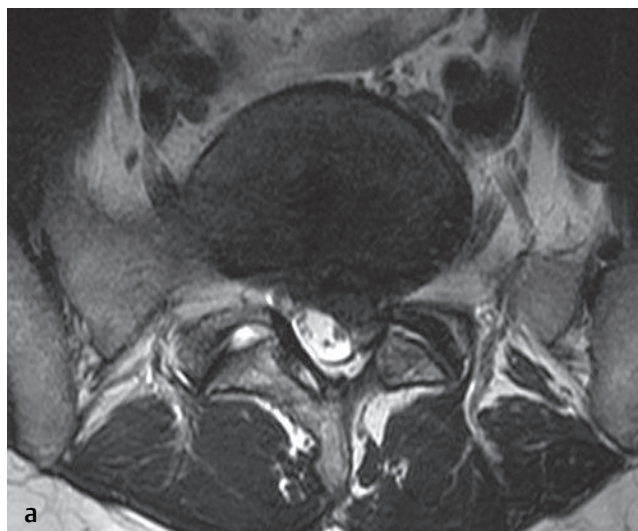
Multiple nerve root contact. (a) This axial T2-weighted image shows a moderate-sized left paracentral disc extrusion at the L5-S1 level (with a foraminal component) producing compression of the traversing left S1 nerve root. (b) A parasagittal T2-weighted image shows the foraminal component of the L5-S1 disc extrusion contacting the exiting left L5 nerve root. This patient presented with radicular pain along both the L5 and S1 dermatomal distributions.
